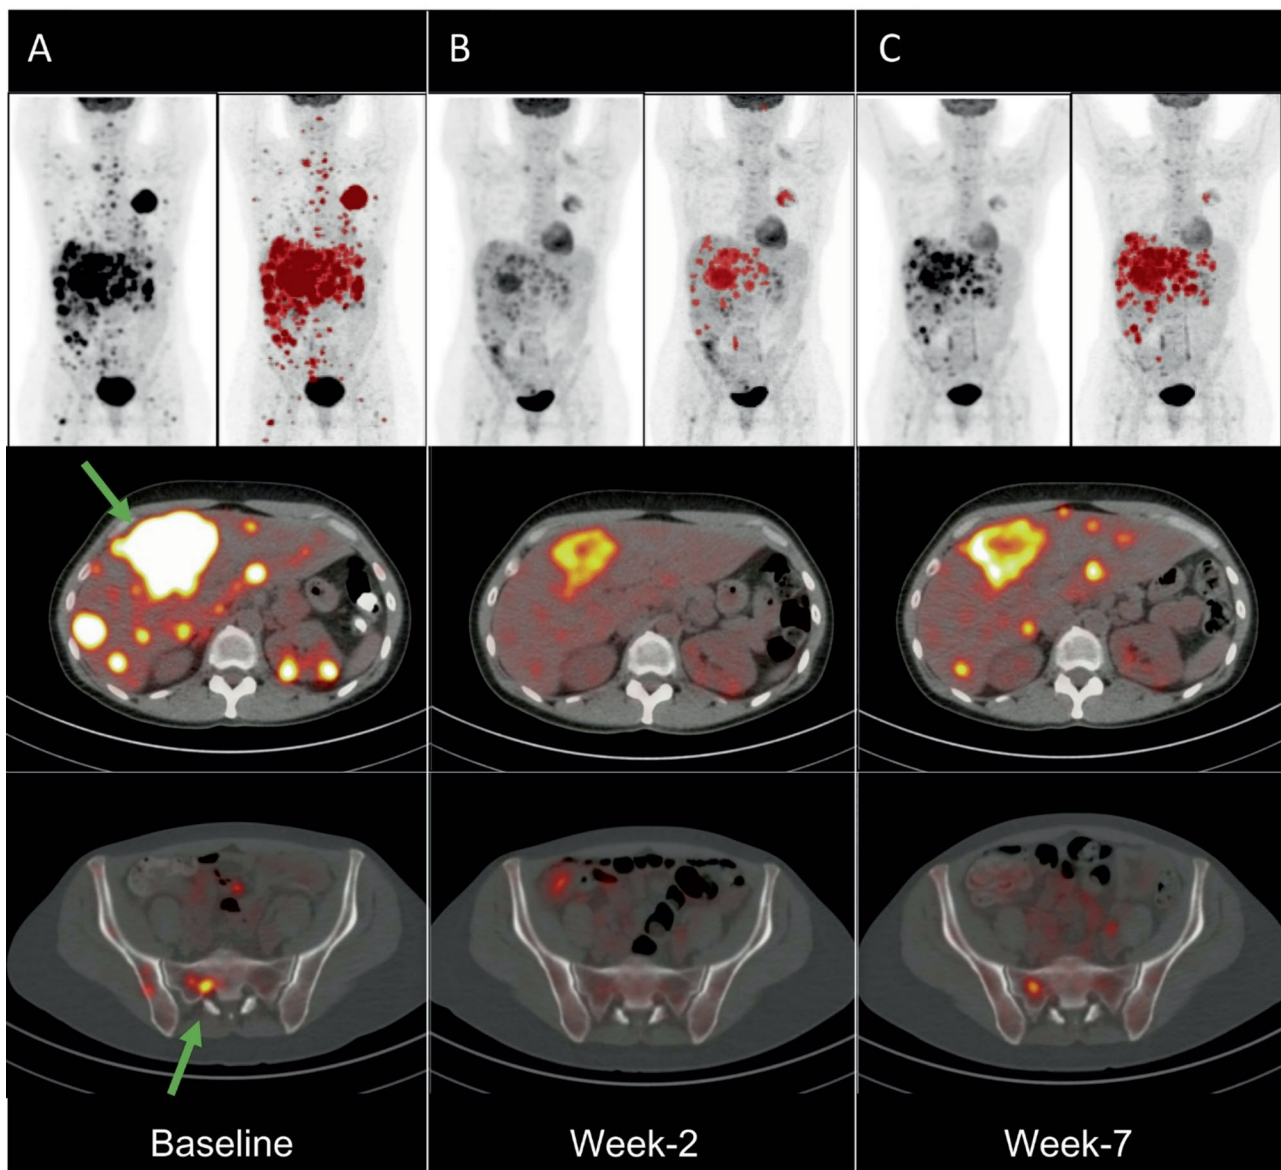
[^{18}F]FDG PET/CT of a patient with early increased metabolic tumor volume after initial response. [^{18}F]FDG PET/CT of a patient at baseline (A), week-2 (B) and week-7 (C). Maximum Intensity Projection without and with (in red) total tumor burden delineation (upper images). Transaxial fusion images of the liver (middle images) and pelvis (lower images). The images demonstrate a decrease in metabolic tumor volume at week-2, but an increase in MTV at week-7, however with an MTV still less than baseline (green arrows and tumor delineation in red)
